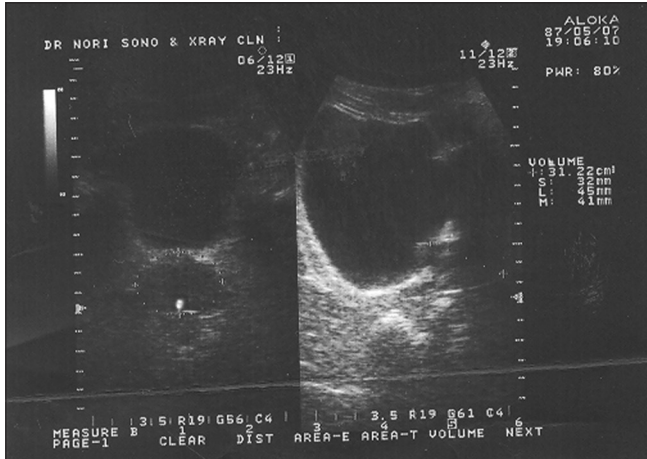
Ultrasonography of the inguinal area shows a large intrascrotal mass
